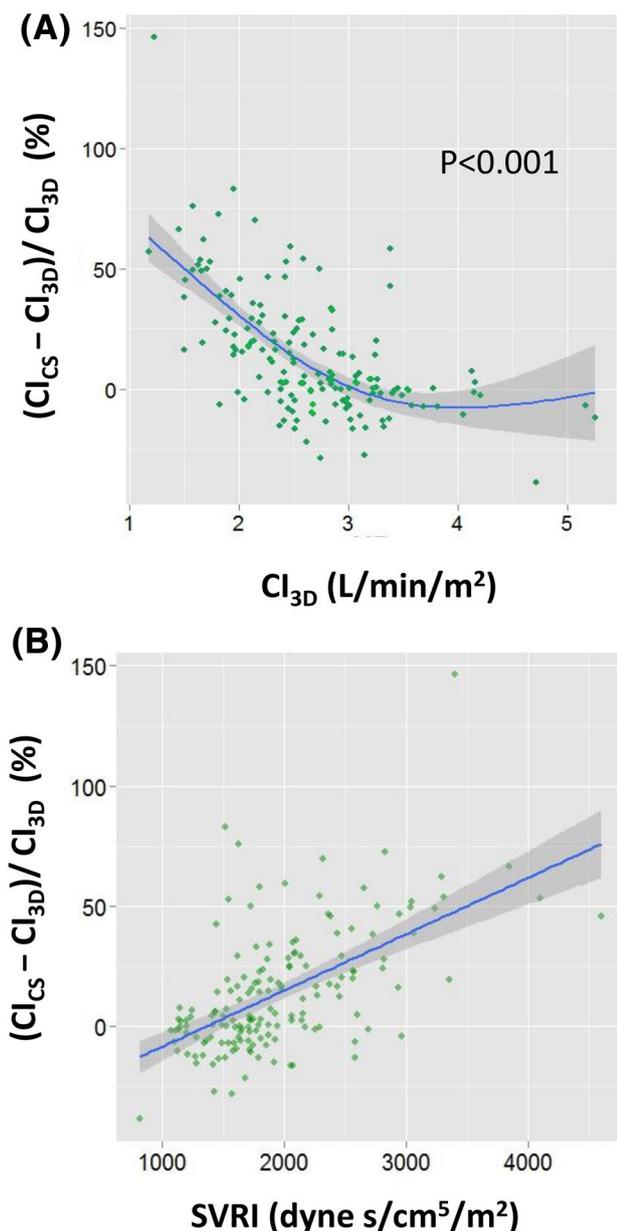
a Cubic spline function curves of the relation between the CI_{3D} and CI discrepancy $[(CI_{CS} - CI_{3D})/CI_{3D}]$. b Cubic spline function curves of the relation between $SVRI_{3D}$ and CI discrepancy $[(CI_{CS} - CI_{3D})/CI_{3D}]$. CI cardiac index, CI_{3D} cardiac index determined with 3D transesophageal echocardiography, CI_{CS} ClearSight™-derived cardiac index, $SVRI_{3D}$ systemic vascular resistance index. Shaded areas represent 95% confidence intervals
